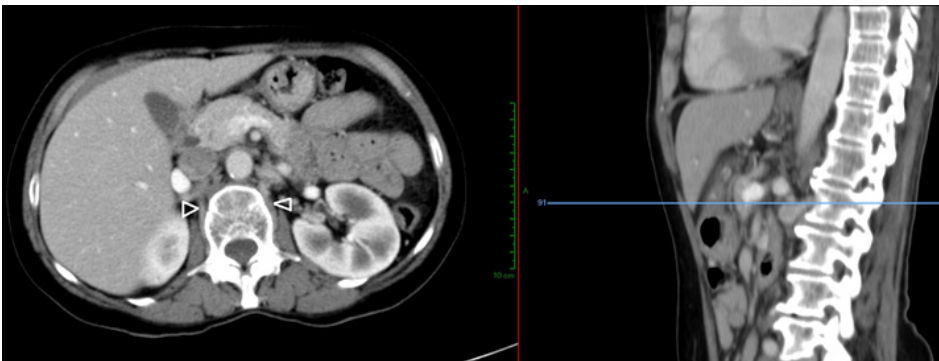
Axial CT image, and the corresponding level on sagittal at the right side of the image, showing the right and left ascending lumbar veins (arrowheads); the left vein is somewhat more prominent than the right one.
